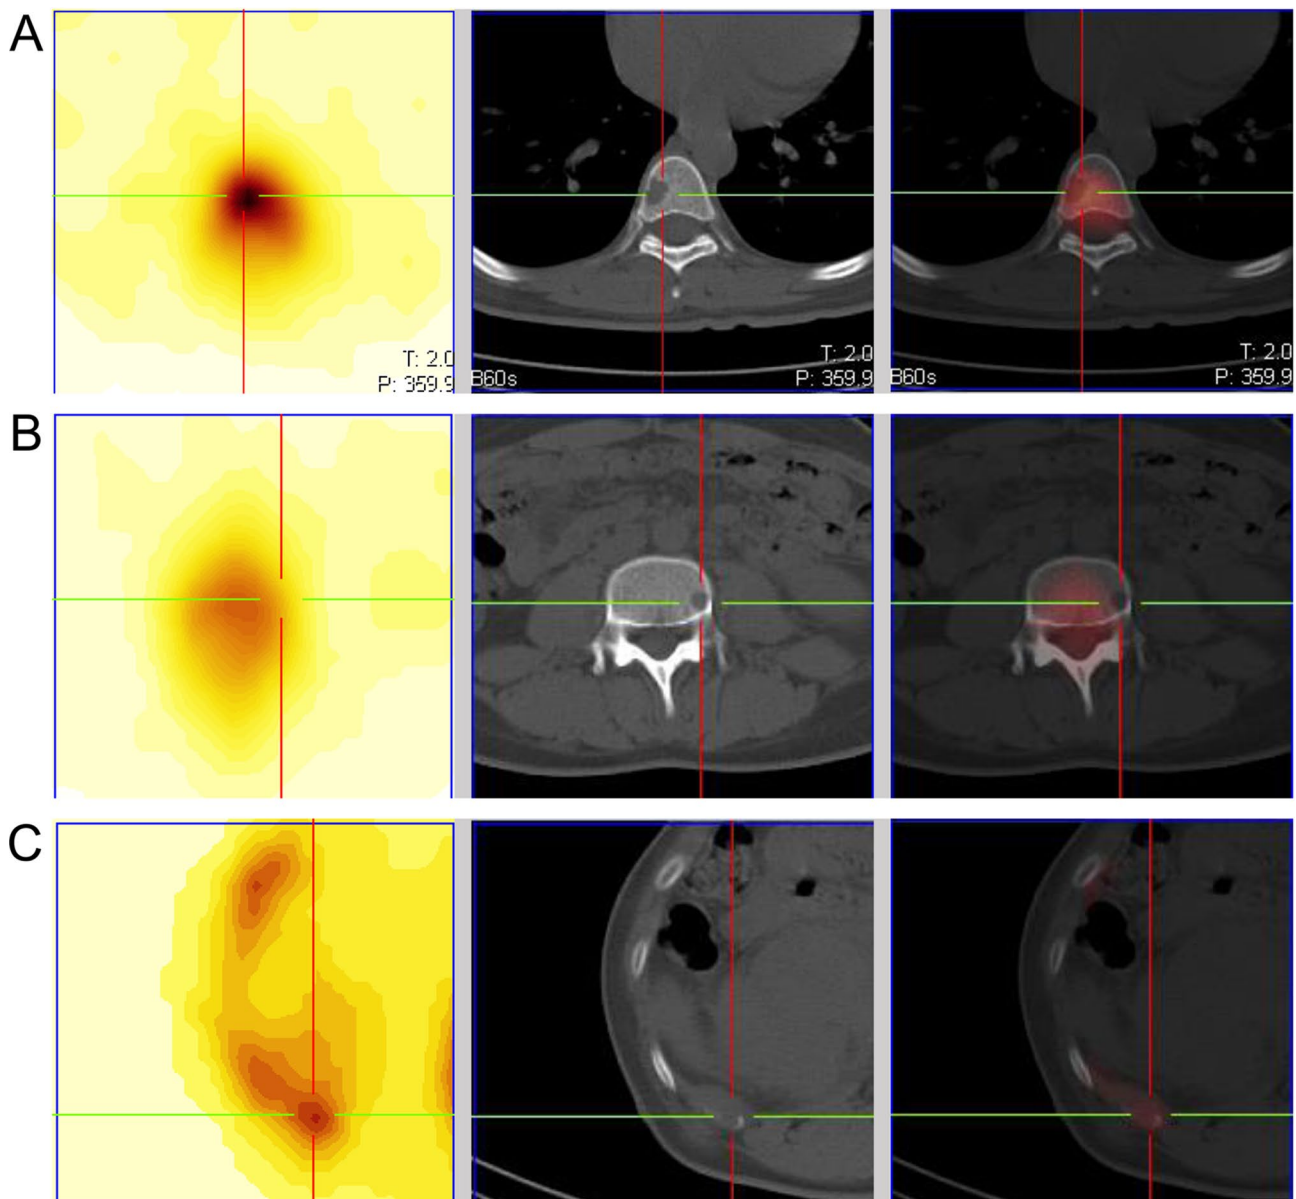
SPECT/CT images showing the metastatic foci. (A-C) the metastatic foci in the 8th thoracic vertebrae (A), the 4th lumbar vertebrae (B), and the left 12th rib (C)
